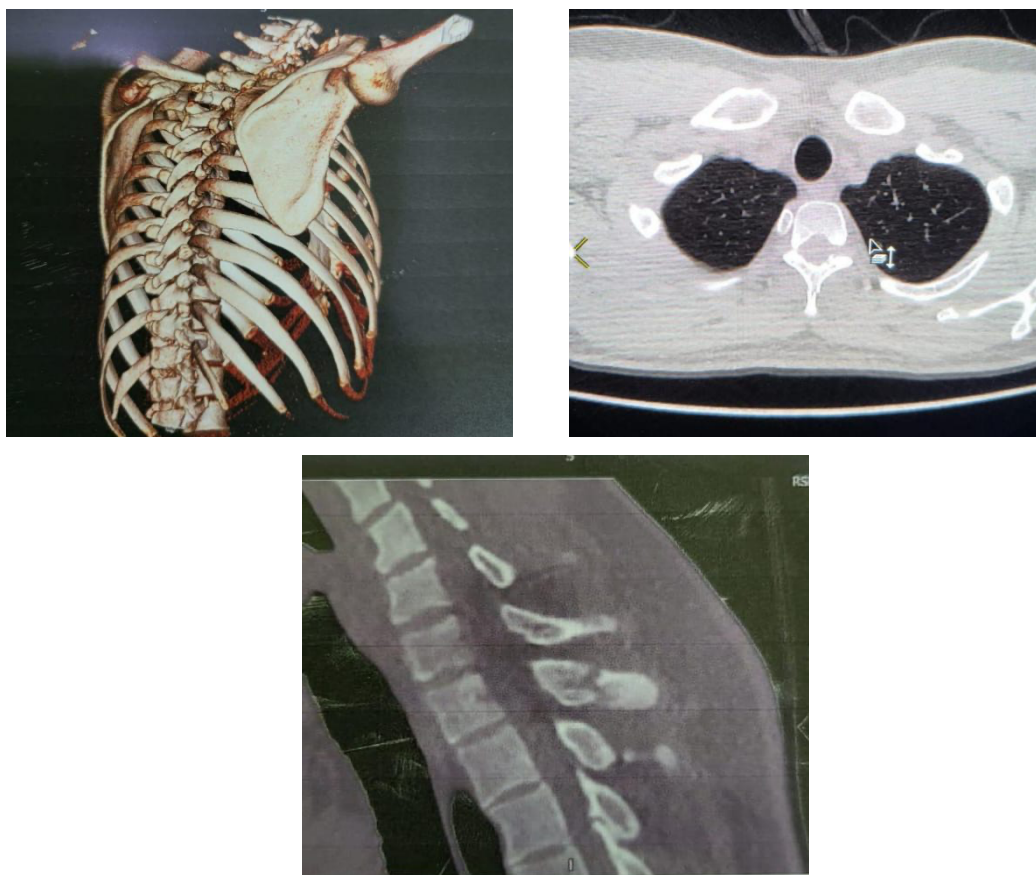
Computed Tomography Revealed Displaced Fractures in the Spinous Processes of Vertebrae T1 and T2
